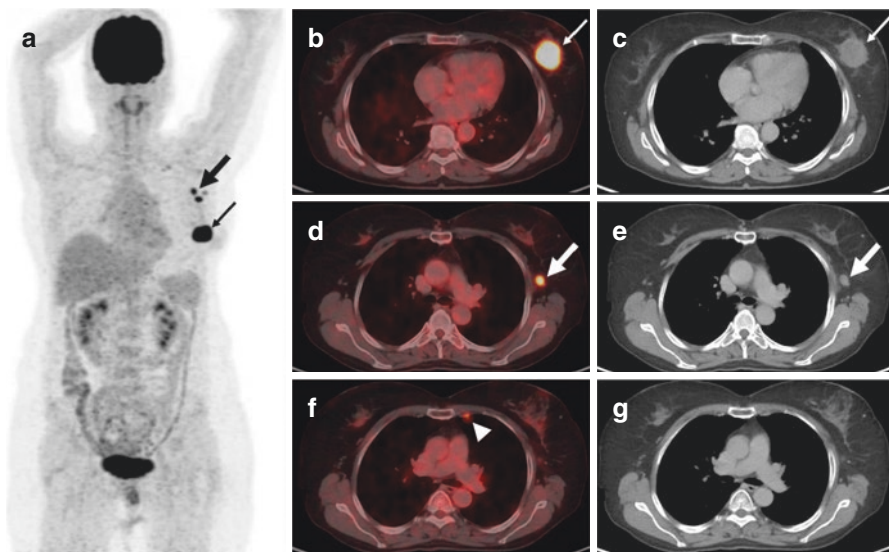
60 year-old-woman with newly diagnosed carcinoma left breast (biopsy – IDC, grade II). A CT chest done for staging showed presence of a left breast mass and involved left axillary lymph nodes. ^{18}F -FDG PET/CT was performed for initial staging. Maximum intensity projection (MIP) image (a), trans-axial fused PET/CT (b) and CT (c) images show intensely tracer avid left breast mass (thin arrow), left axillary nodal disease (d, e; thick arrow) and additional involvement of a sub-centimetric left internal mammary lymph node (f - arrow-head, g). ^{18}F -FDG PET/CT upstaged the patient to AJCC stage IIIC. Physiological radiotracer activity is also seen in the brain, liver, kidneys, intestines and urinary bladder in the MIP image
